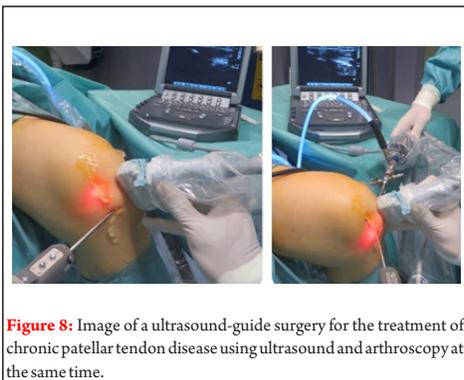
Image of an ultrasound-guide surgery for the treatment of chronic patellar tendon disease using ultrasound and arthroscopy at the same time.
